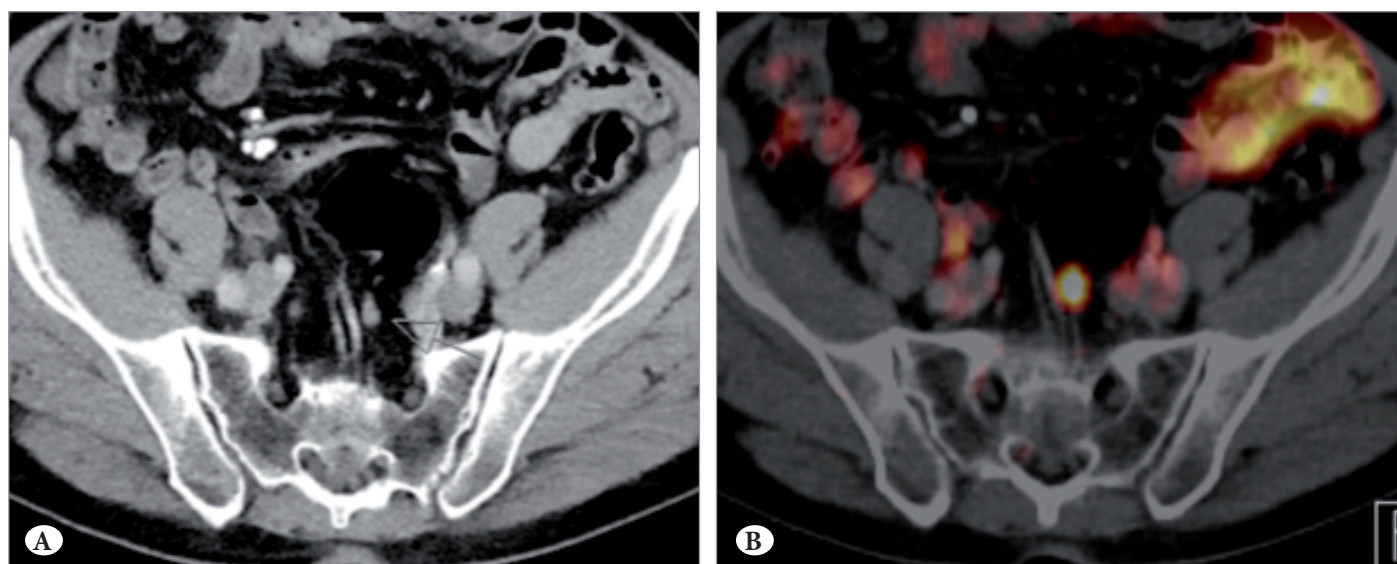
81 year old patient with biochemical recurrence after radical prostatectomy. Contrast enhanced CT images (A) shows small lymph node in the pelvis, ⁶⁸Ga-PSMA ligand PET (B, fusion images) shows intensive PSMA expression of the lymph node. Consecutive surgery verified lymph node metastasis.
